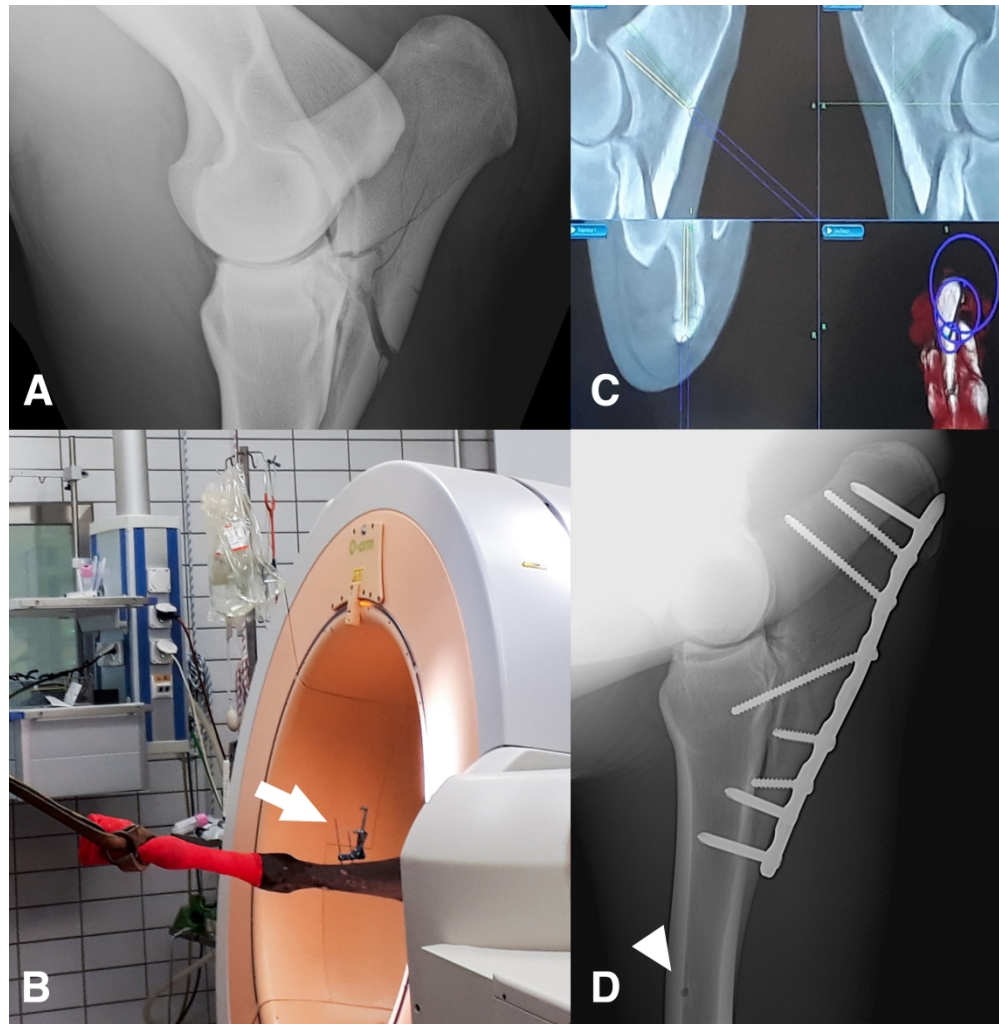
Plate fixation of a chronic, comminuted articular ulna fracture (case 12): (A) Preoperative mediolateral radiograph. (B) Photograph of the preoperative image acquisition. Note that the large-bore gantry of the O-arm is slightly tilted to ensure that the entire olecranon process lies within the imaging isocenter, and the position of the patient tracker (arrow) on the antebrachium. (C) Intraoperative photograph of the surgeon monitor at the beginning of the drilling procedure. Note the green corridor planned for the first screw. The surgeon is still adapting the orientation of the drill, as the projection of the drill bit (yellow cylinder) is not yet overlapping with the preoperative plan. (D) Mediolateral radiograph taken three months postoperatively. One of the pin-holes for anchoring the patient tracker is still visible in the diaphysis of the radius (arrow head).
